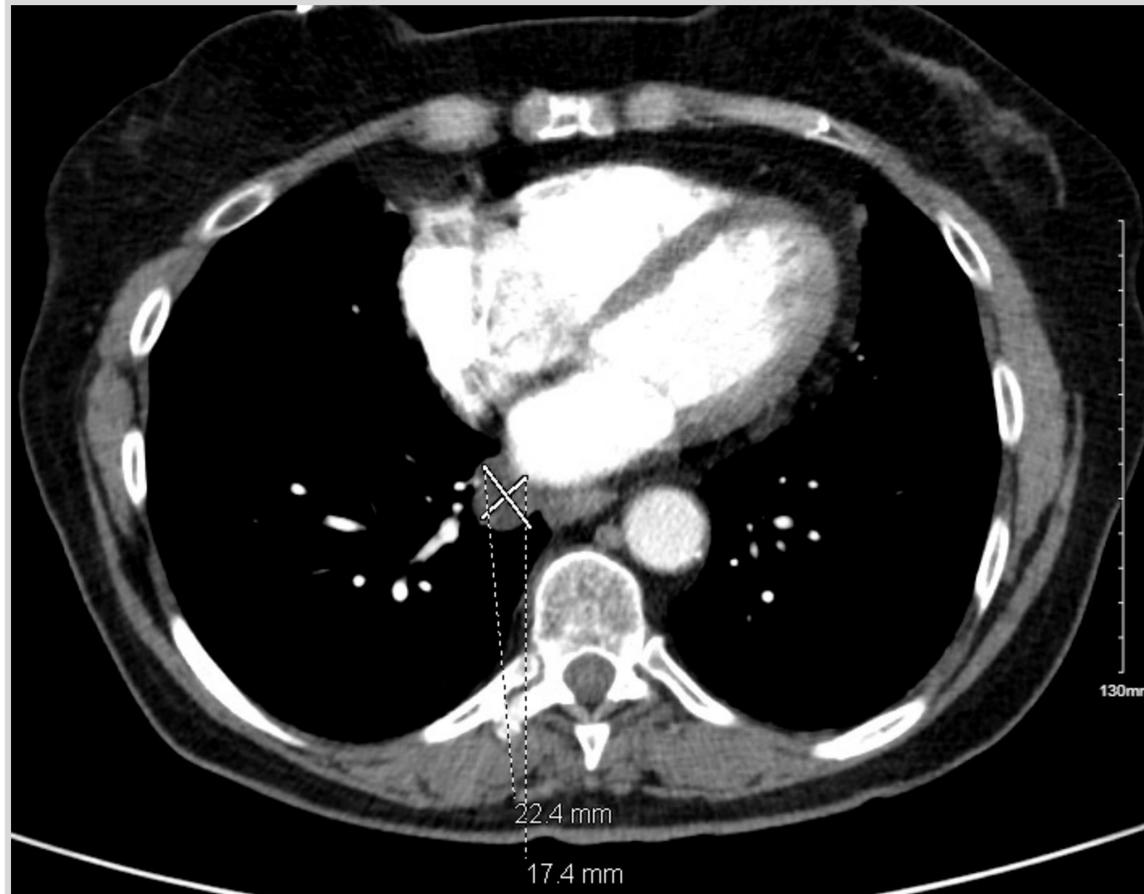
CT chest showing pericardial cyst measuring 22 x 17 mm (red arrow)
